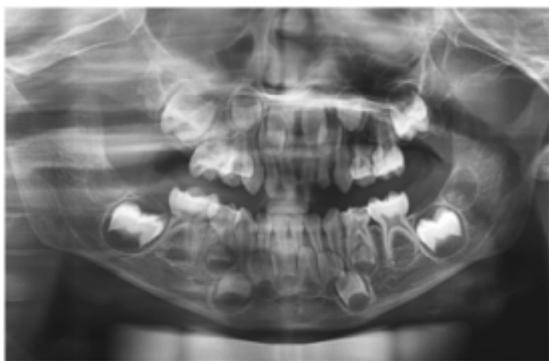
a: Pre- operative Orthopantomogram
